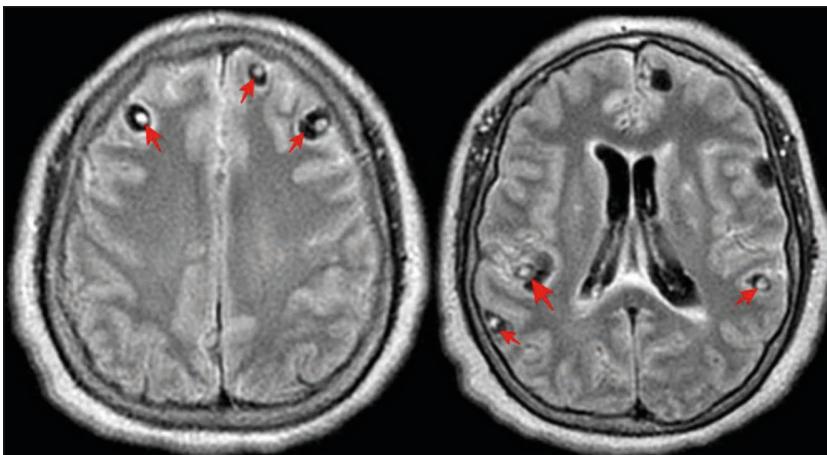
Gadolinium-enhanced axial FLAIR-weighted brain MRI (September 25th, 2019), showing several cystic lesions with central hyperintense content (scolex) compatible with multiple viable NCC (red arrows).
